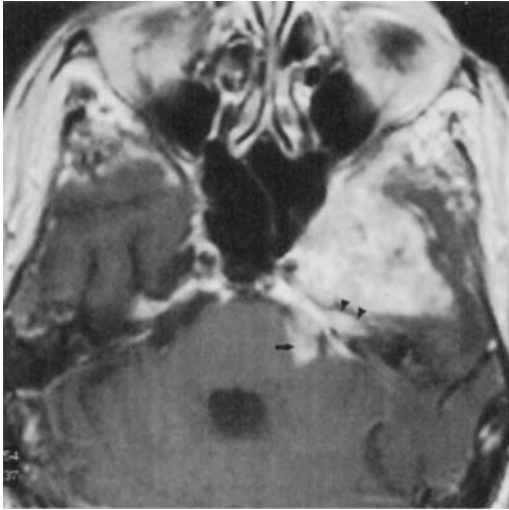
Perineural spread of adenocarcinoma arising from the parotid gland. Intracranial spread of malignancy is apparent on this postgadolinium T1-weighted MR image. There is spread of tumor in the left middle cranial fossa, cavernous sinus, internal auditory canal (*arrowheads*), and cisternal portion of the trigeminal nerve (*arrow*), resulting from perineural spread along the mandibular division of the trigeminal nerve through the foramen ovale.
